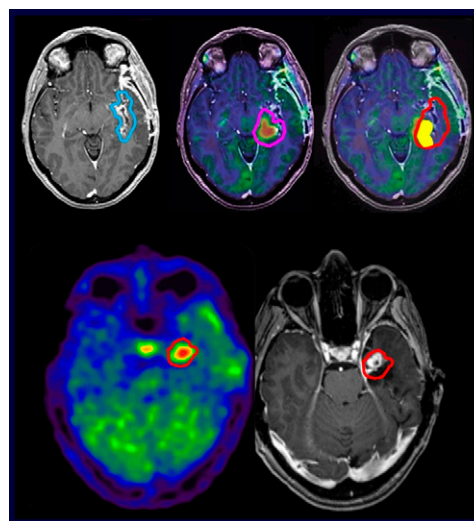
^{11}C -methionine PET/CT and MR in glioblastoma. Top: Gross tumor volume (GTV) on MR (left) and ^{11}C -methionine PET/CT (middle) yielded a median 3.12 cc of volume (range, 0.84–0.848) not identified on MR imaging alone. Bottom: Recurrence volume on MR imaging (right) matched areas of highest uptake on ^{11}C -methionine PET/CT (left) in 33 of 46 patients.
